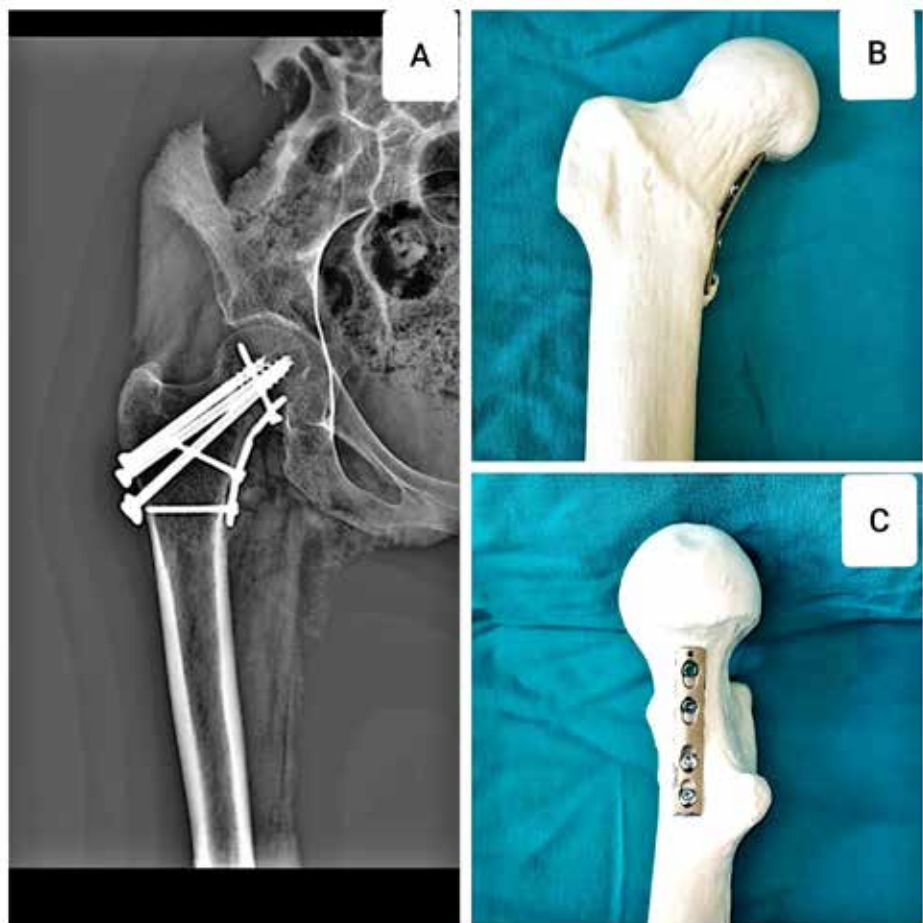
A) Postoperative anteroposterior radiograph showing that union was observed. Semi-tubular plate placed on the femur anteromedial surface of a synthetic bone model; B) Anteroposterior image, C) Inferior image.
